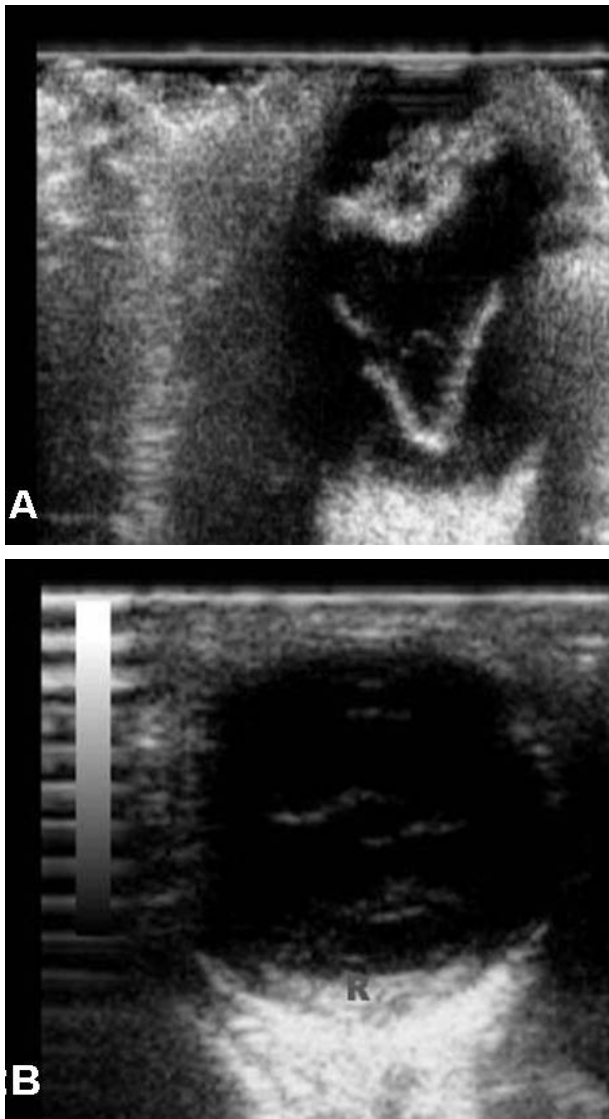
Ultrasonography image. A: Ultrasonography image (12 MHz linear probe) showing complete retinal detachment coursing from their attachment at optic disc up to ora serrata. B: Ultrasonography image (10 MHz linear probe) showing flat retinal detachment (R) with vitreal degeneration (VD)
